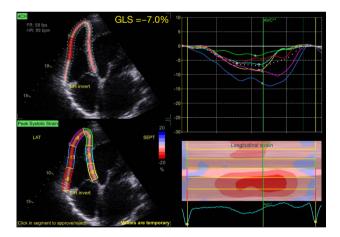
Echocardiographic images of one of the participants showing right ventricular global longitudinal strain (RV GLS= -7.0%) on the left panel, the strain curves and the strain map on the right panel respectively. 4CH, 4-chamber view; FR, frame rate; HR, heart rate; L/R, left/right invert; LAT, lateral; SEPT, septal; AVC, aortic valve closure line; RV, right ventricle; GLS, global longitudinal strain.
